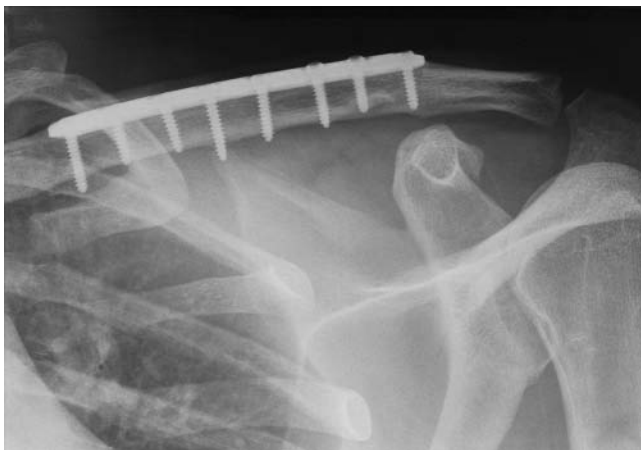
Radiograph showing a healed fracture.
